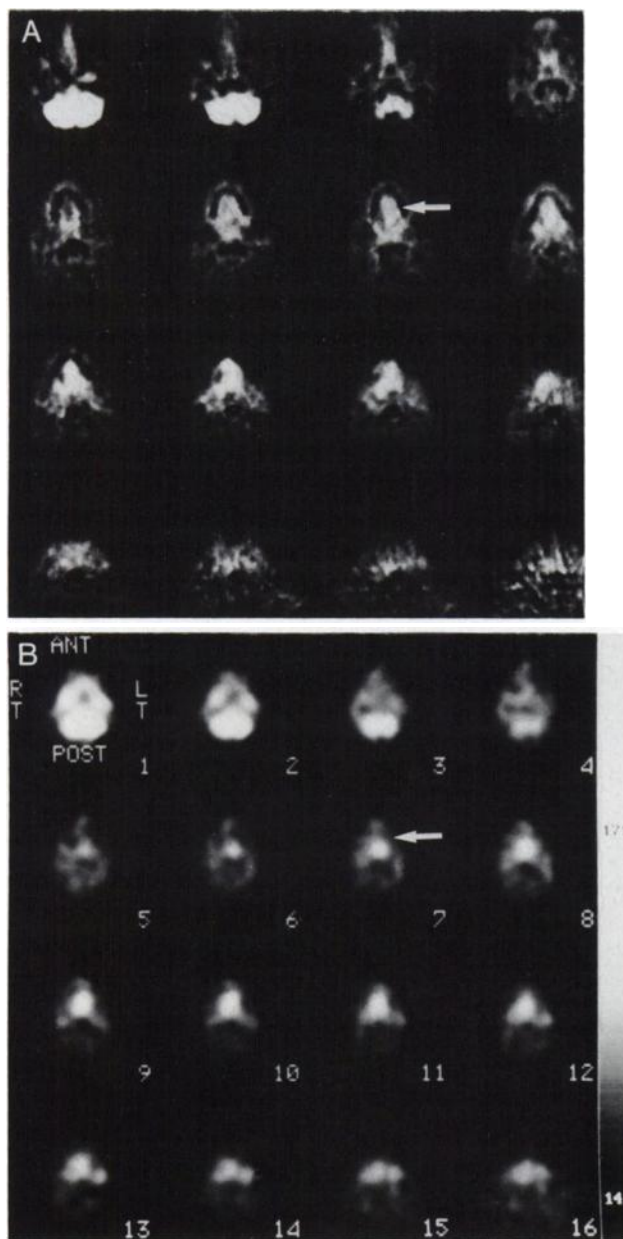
A 41-yr-old man with a recurrent squamous-cell carcinoma of the tongue, irradiated 3 mo prior to the scan. (A) ^{18}F -FDG-PET: axial images show an area of increased uptake in the region of the posterior tongue (arrow). (B) ^{18}F -FDG-SPECT: axial images show the same area of increased uptake as the ^{18}F -FDG-PET scan (arrow).
